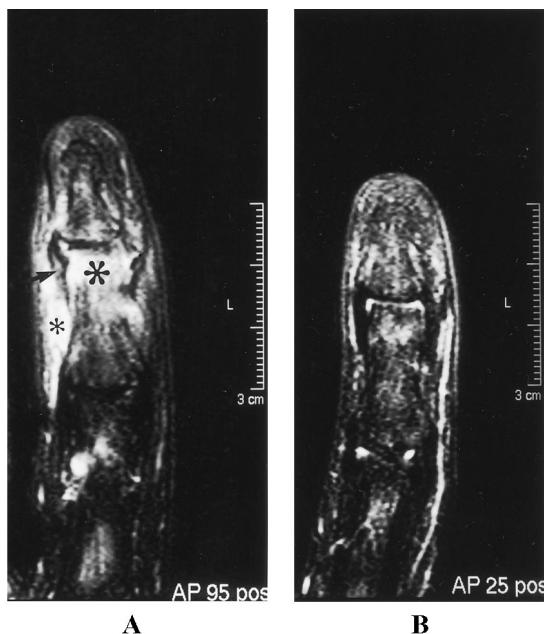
T1-weighted fat-suppressed post-gadolinium coronal sequence of the left second distal interphalangeal joint of a patient with undifferentiated spondylarthropathy. A, Appearance at baseline, before treatment with etanercept. There is extensive subcutaneous edema (small black asterisk) and bone marrow edema (large black asterisk) with inflammatory change within the collateral ligament (black arrow). B, The same joint after 6 months of treatment with etanercept, showing marked improvement of all the features described.
